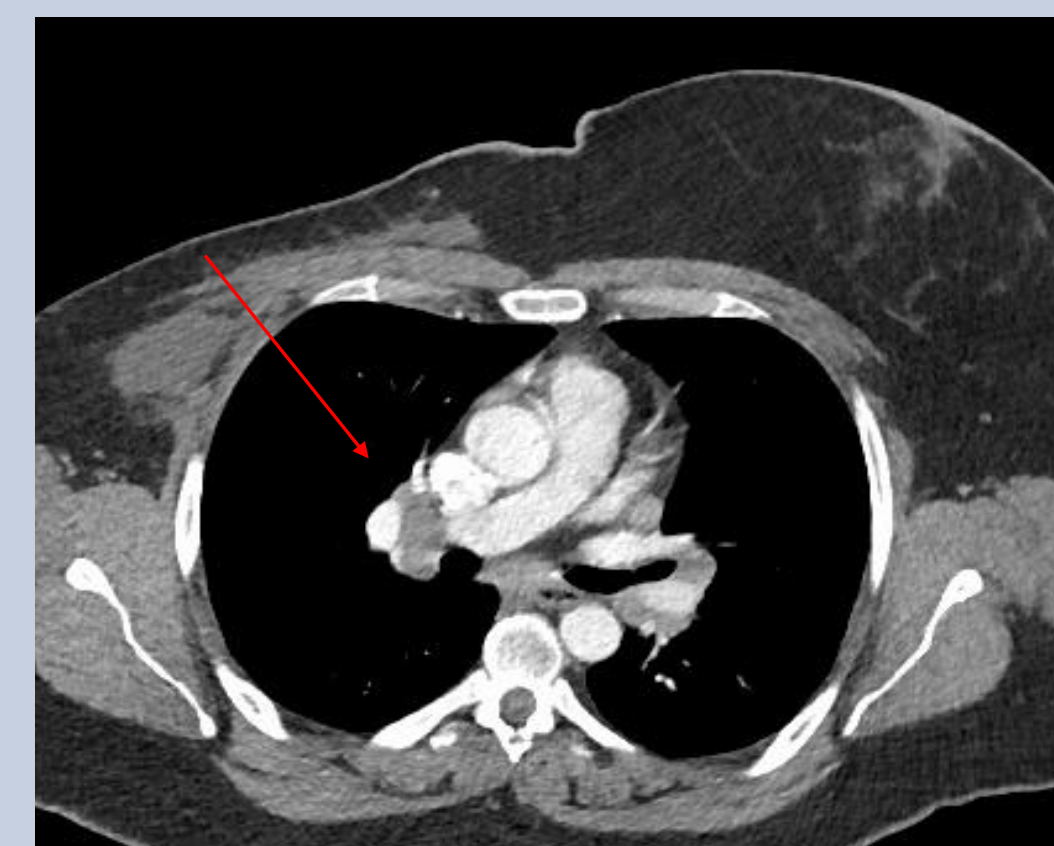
Axial CT demonstrating right mastectomy and right hilar lymph node
